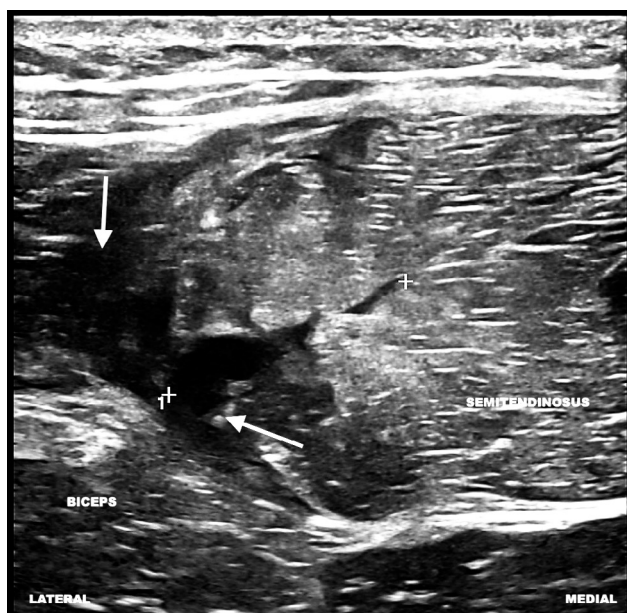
A 15-year-old male felt a sudden “pop” after stretching his leg to reach the ball while training. An ultrasound image in the transverse plane of the semitendinosus muscle showing a partial tear of the muscle fascicles and a complete tear of the conjoint tendon, where there was an anechoic collection (arrows). SOMICS category 3 (score of 11).
